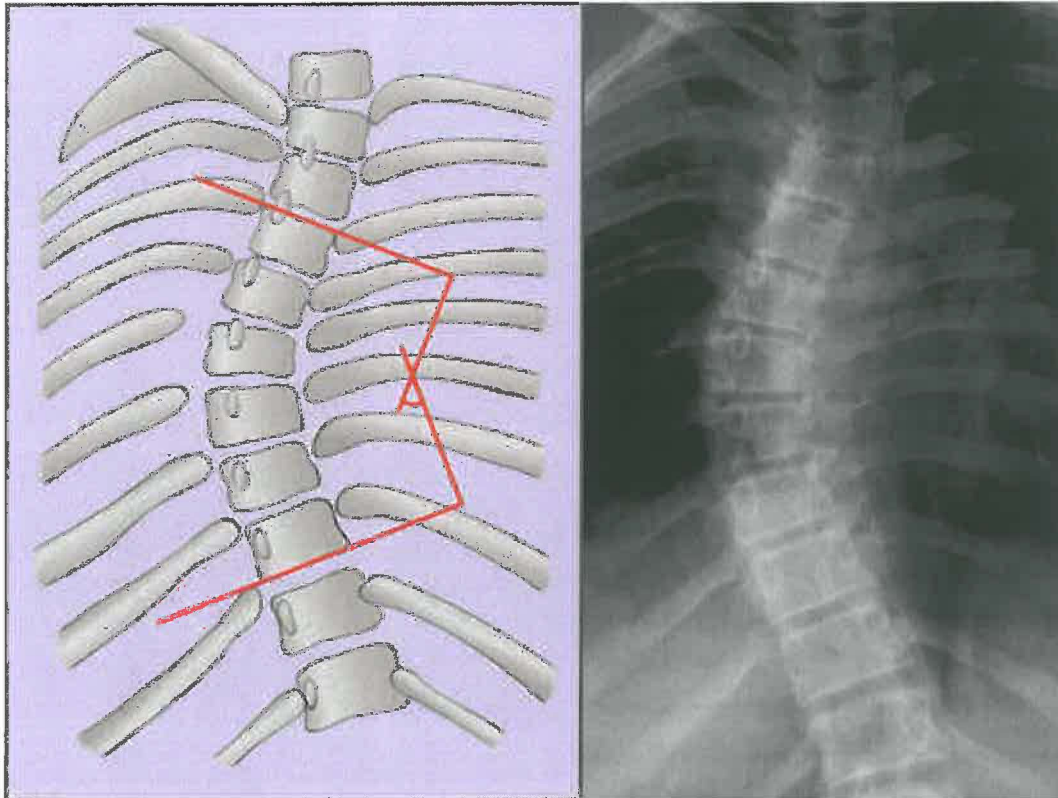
Cobb's Angle and Xray (Oldnall Nick, Review of Cobbs angle, March 2008)
